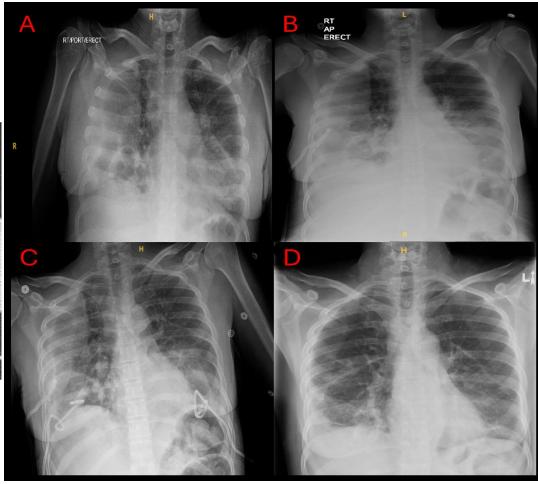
Serial chest radiographs: A) Day 5 of admission, before chest tube insertion. B) Day 8 of admission after right sided chest tube insertion. C) Day 11 of admission after left sided chest tube insertion. D) Day 24 of admission before discharge, with both chest tubes removed and after intrapleural lytic therapy.
